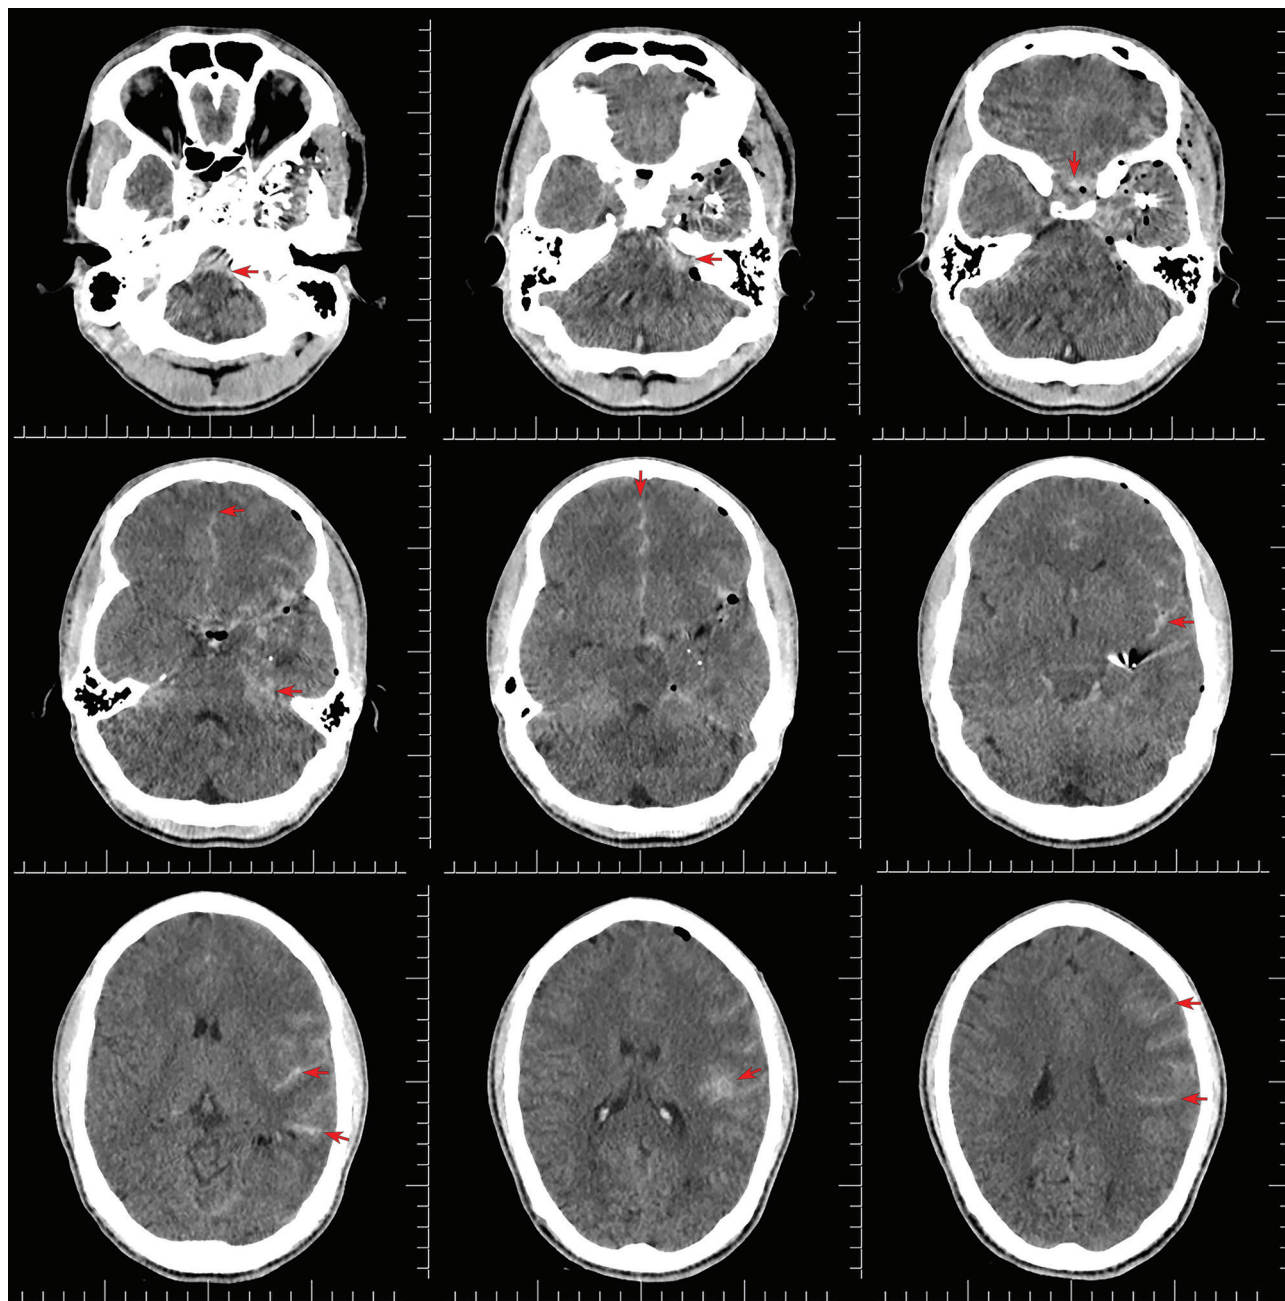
Axial slices of head CT without contrast in the brain window show bleeding in the frontal, parietal and left temporal subarachnoid spaces with extension to the sylvian fissure, interhemispheric space and base cisterns (red arrows).
